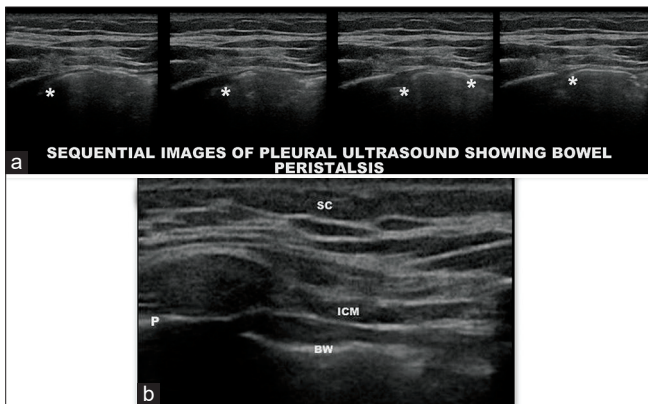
(a and b): Sequential images of bowel peristalsis in pleural/lung ultrasound using linear probe (5–12 MHz) (video part has been uploaded in video section) (SC: Subcutaneous tissue, ICM: Intercostal muscle, P: Pleura, BW/*: Bowel wall)
